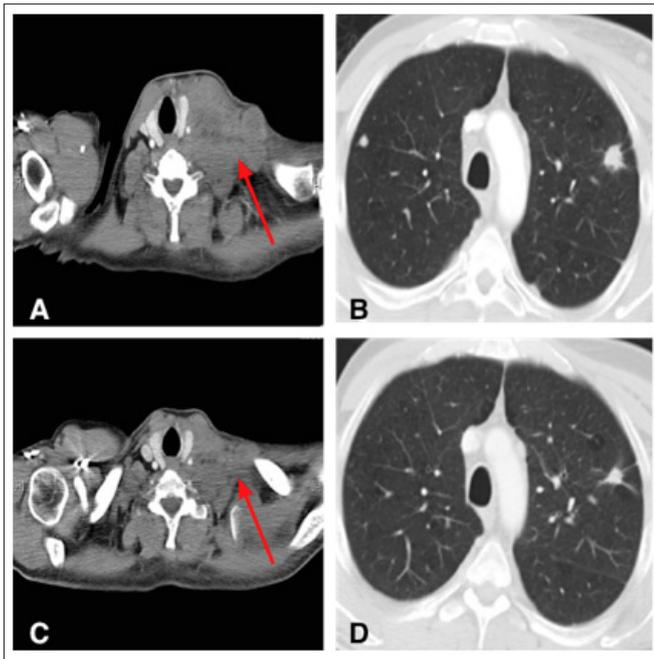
CT scan of patient with squamous non-small cell lung cancer. A and B. CT scan prior to commencing treatment with Nivolumab. Cross sectional imaging of A. neck and B. lung C and D CT scan following one month of Nivolumab treatment demonstrating response to treatment. Cross sectional imaging of C. neck and D. lung.
